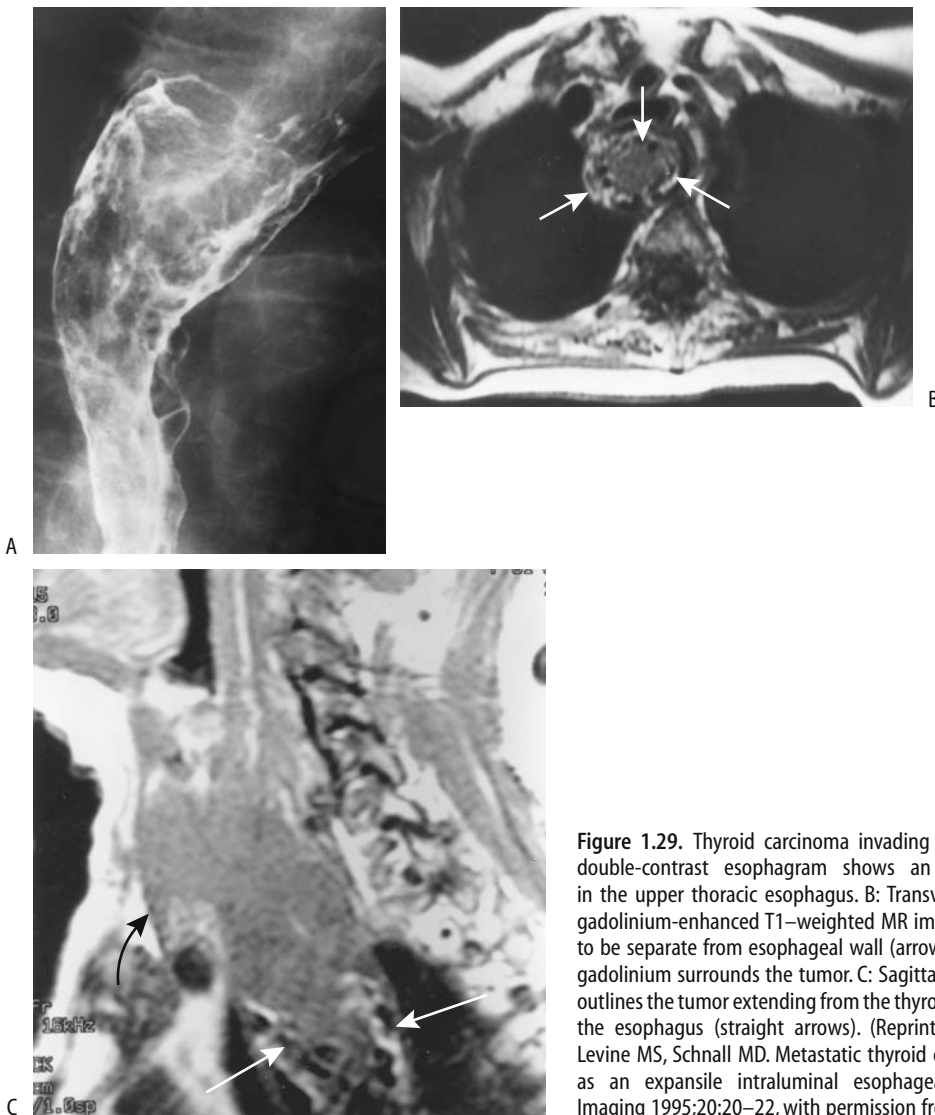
Thyroid carcinoma invading the esophagus. A: A double-contrast esophagram shows an intraluminal tumor in the upper thoracic esophagus. B: Transverse postintra-venous gadolinium-enhanced T1-weighted MR image shows the tumor to be separate from esophageal wall (arrows). Hyperintense oral gadolinium surrounds the tumor. C: Sagittal T1-weighted image outlines the tumor extending from the thyroid (curved arrow) into the esophagus (straight arrows). (Reprinted from Cooney BS, Levine MS, Schnall MD. Metastatic thyroid carcinoma presenting as an expansile intraluminal esophageal mass. *Abdominal Imaging* 1995;20:20–22, with permission from Springer.)
